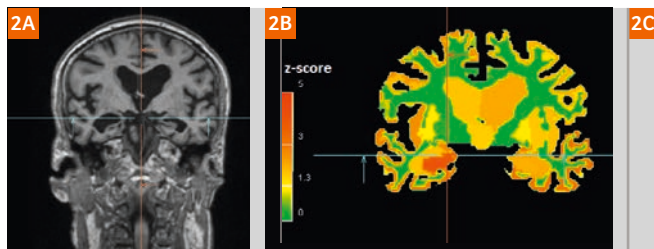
Screenshots of MorphoBox results on the *syngo* viewer for an Alzheimer's Disease patient. (2A) an MRI coronal slice, (2B) the corresponding deviation map, and (2C) three pages from the report.
